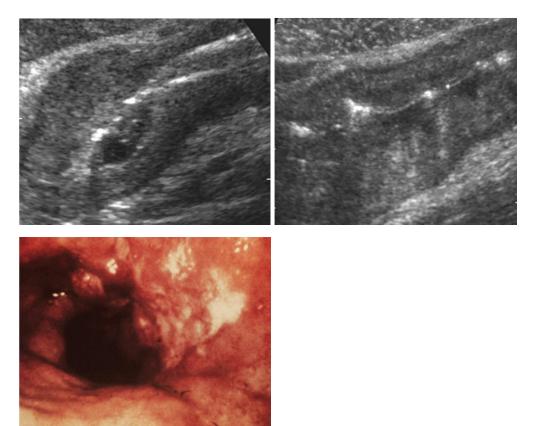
a-c Linitis plastica ("leather bottle stomach") bilateral of gastric antrum and body, sonographic (a, b) and endoscopic (c) aspect limited to mucosa, local pressure pain; UAS transverse (a, b)
